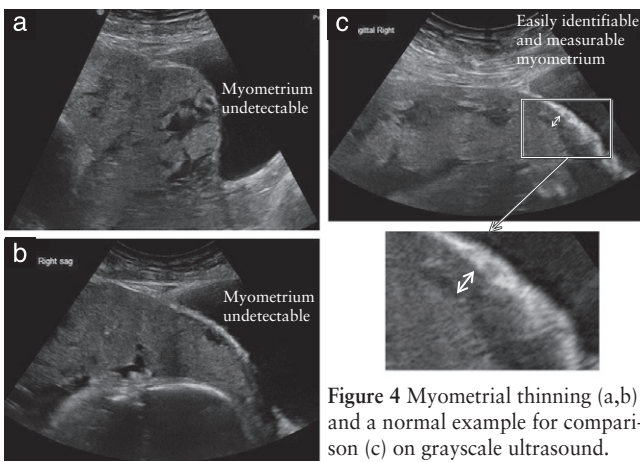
Myometrial thinning (a,b) and a normal example for comparison (c) on grayscale ultrasound.
